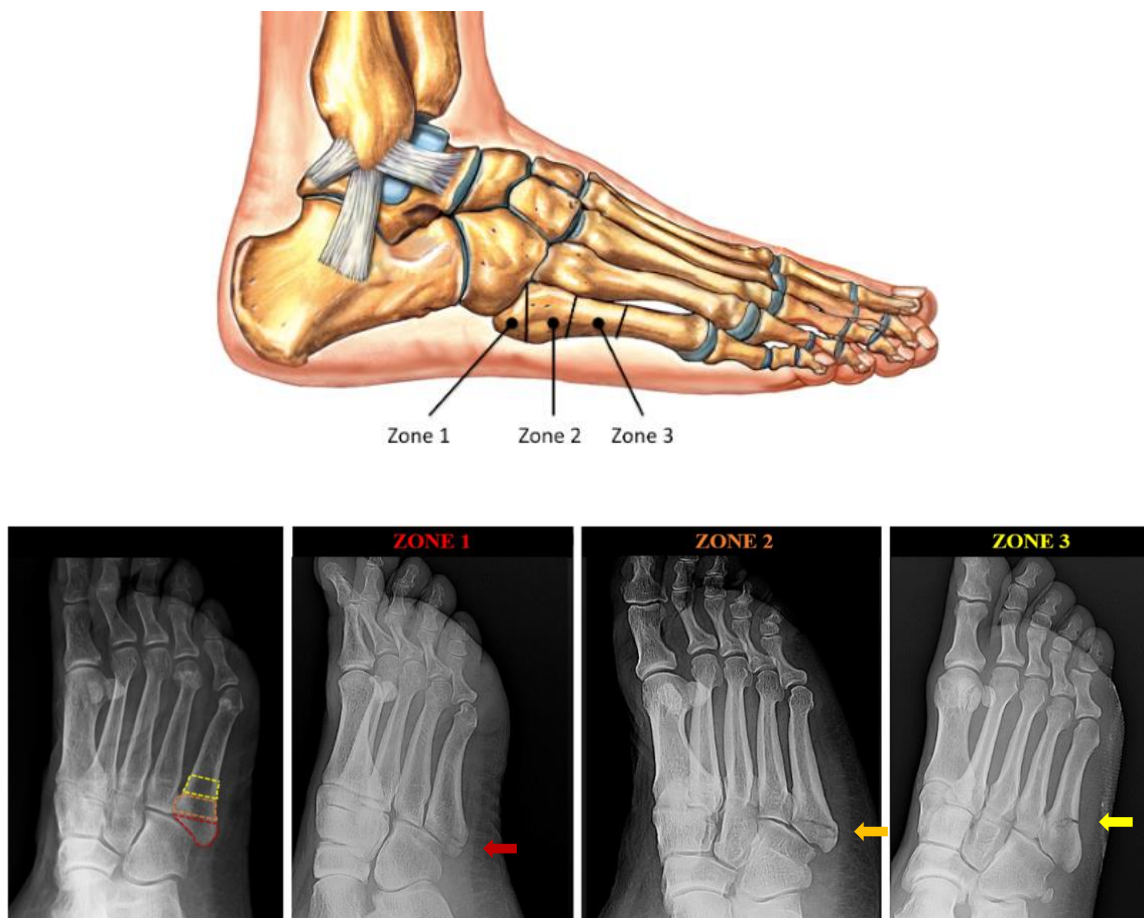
Lawrence and Botte classification of proximal fifth metatarsal fractures. Top: This classification subdivides fractures into three distinct anatomical zones, as labeled on the fifth metatarsal bone. Zone 1= tuberosity avulsion fractures, Zone 2= metaphyseal/diaphyseal junction fractures, and Zone 3= proximal diaphyseal fractures (Ligaments of the Foot and Ankle, 2019). Bottom: Radiographic images for each anatomical fracture zone are labeled. Note that the image on the far left is a non-fractured bone and serves as a reference image for the different zone boundaries (Pugliese et al., 2020).
